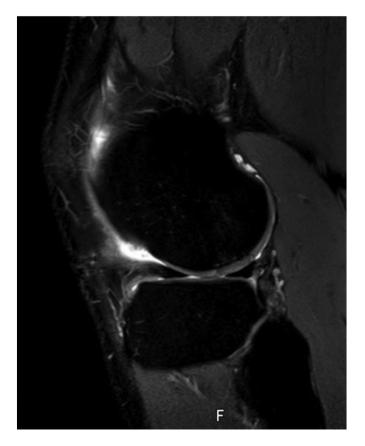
An MRI of the same location 12 months after treatment.
